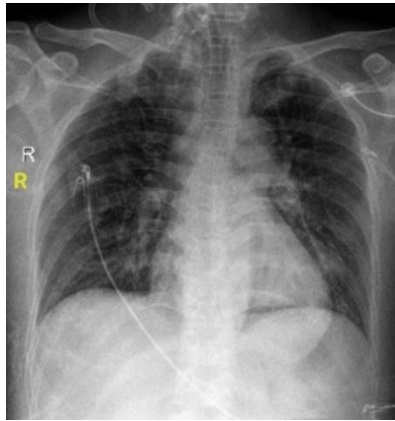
Chest x-ray of the patient that shows pneumonia
